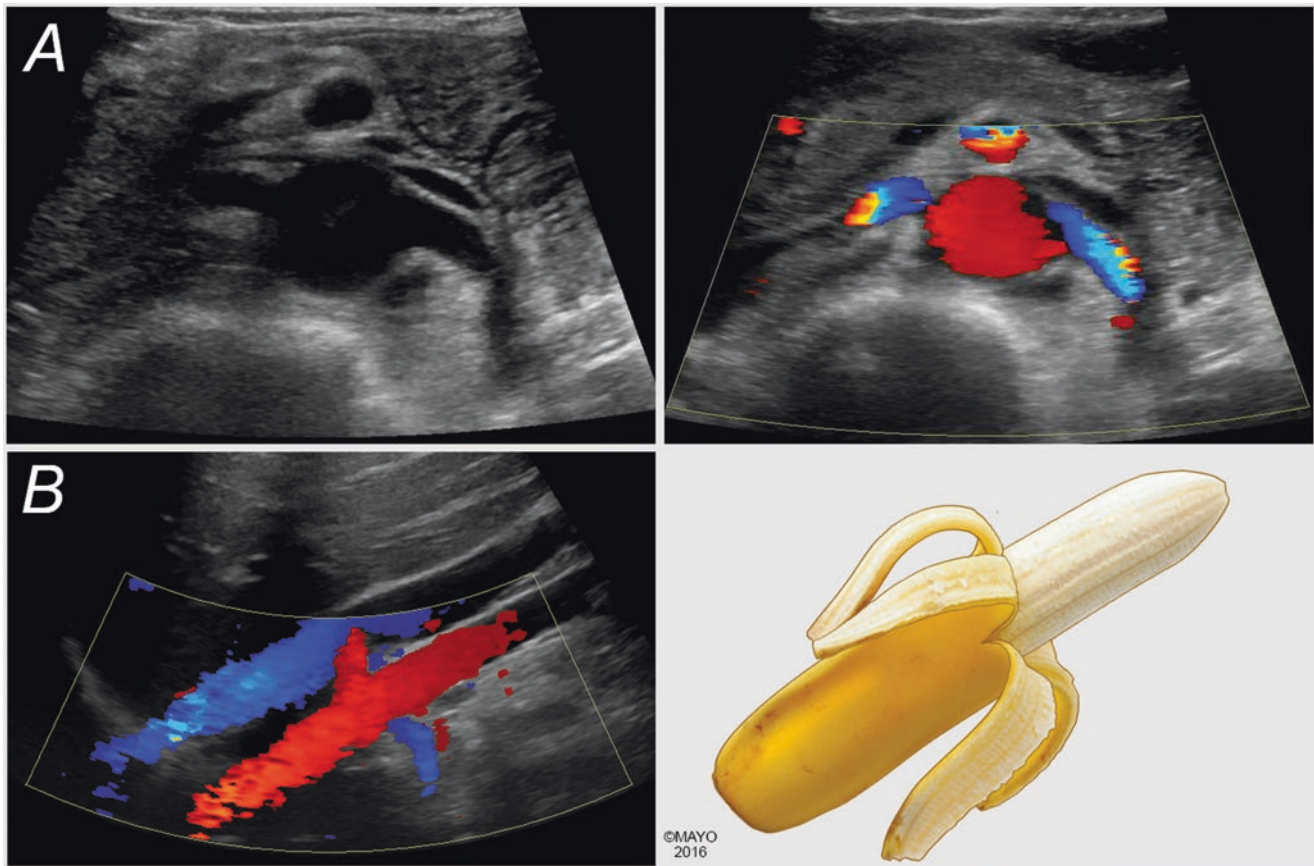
Gray scale and color Doppler of the renal arteries origin. The renal arteries origin can be found with the transducer in transverse plane midline (a). Alternatively, the coronal plane using the liver as a window can be used to obtain the coveted “banana peel” image where
